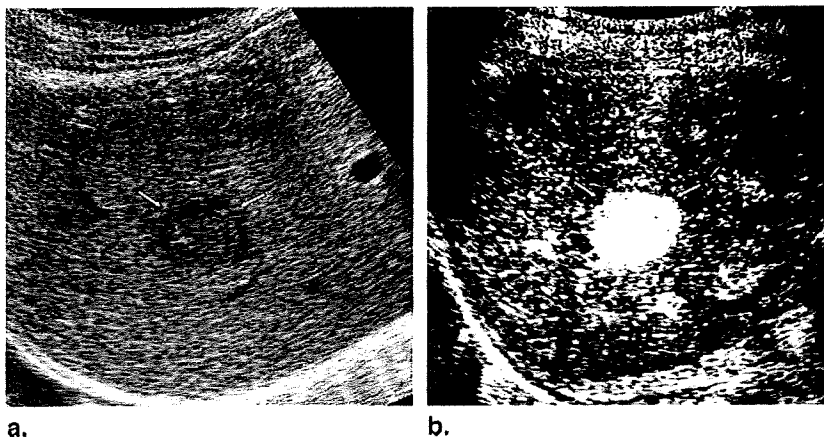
A 73-year-old woman with hepatitis C cirrhosis and hepatocellular carcinoma (*arrows*). (a) Oblique subcostal B-mode ultrasound shows mass (*arrows*) with thin hypoechoic rim in right lobe of liver. (b) In arterial phase, the lesion (*arrows*) shows diffuse homogeneous and fairly hypervascularity relative to liver parenchyma. Percutaneous biopsy revealed moderately differentiated hepatocellular carcinoma.
